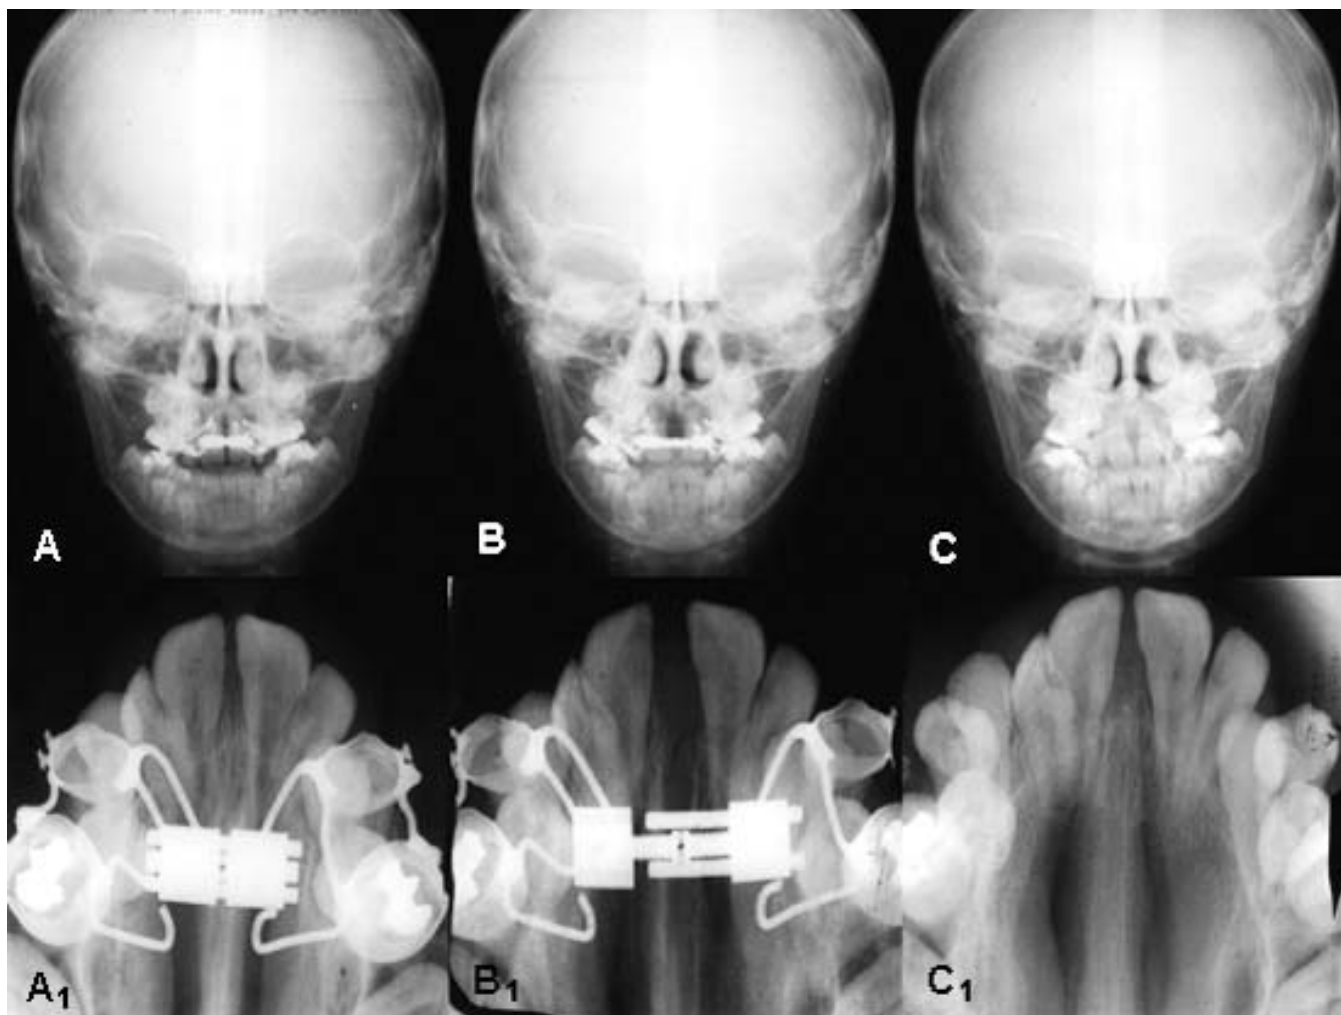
PA cephalograms and occlusal x-rays at pretreatment (A and A₁), postexpansion (B and B₁), and at the time that the maxillary expansion appliance was removed (C and C₁).
